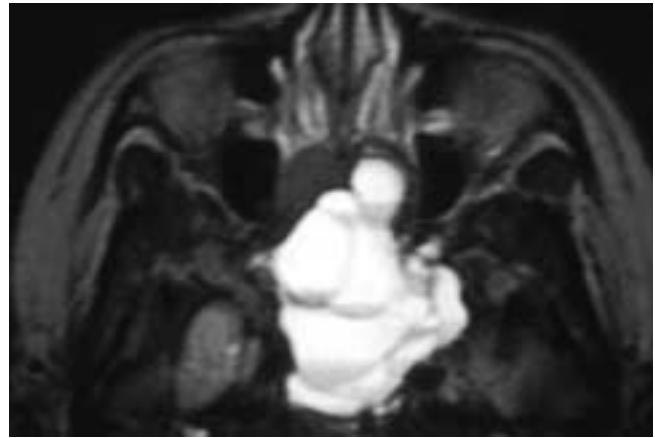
Axial T2-weighted MR image shows a mass in the sphenoid bone and sphenoid sinus. This lesion is composed of multiple cystic areas, each with a fluid-fluid level. This patient had an aneurysmal bone cyst.
